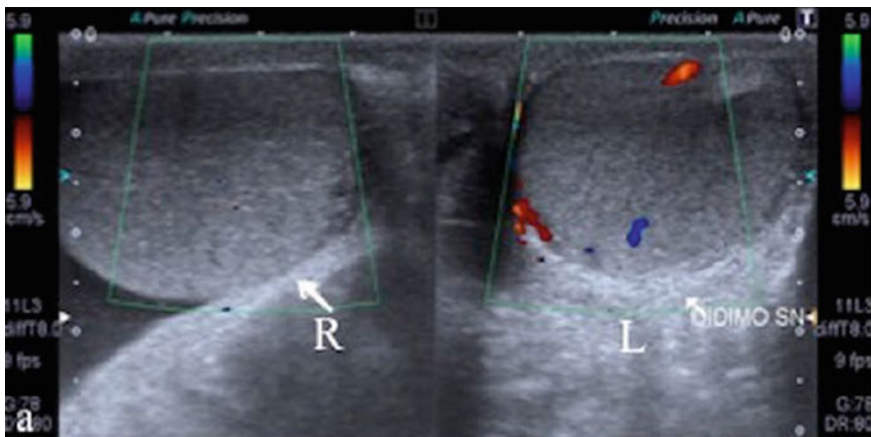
Testicular torsion on doppler US, showing absence of flow in the R testis as opposed to the L testis¹¹
